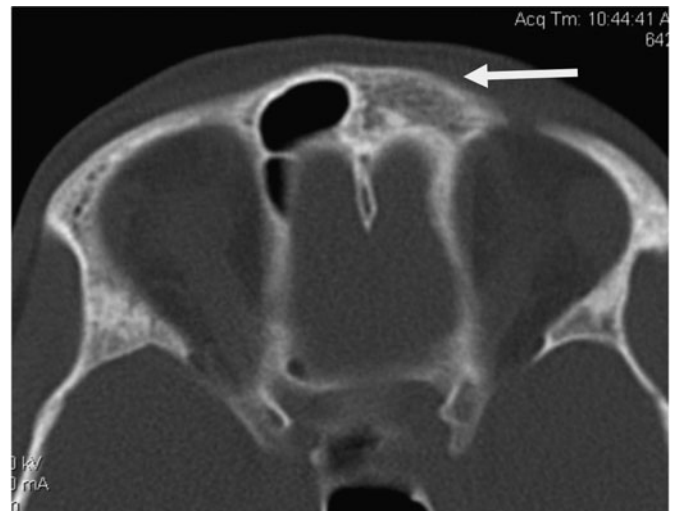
Multi-detector computed tomography axial section of paranasal sinuses shows atretic left frontal sinus. The arrow indicates the atretic left frontal sinus, which ideally should have been filled with air (black); however, there was also bone in its place.
